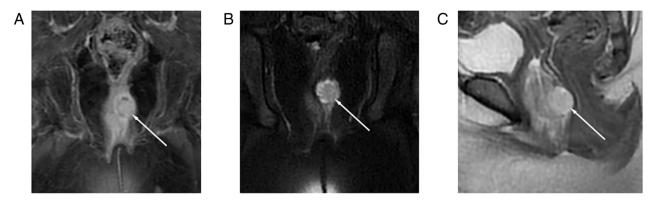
MRI images of the tumor. (A) Coronal section, fat-saturated T1-weighted imaging. (B) Coronal section, fat-saturated T2-weighted imaging. (C) Median sagittal section, T2-weighted imaging. The contrast-enhanced MRI scanning results showed a heterogeneous mass (white arrows) occupying the vagina. MRI, magnetic resonance imaging.
